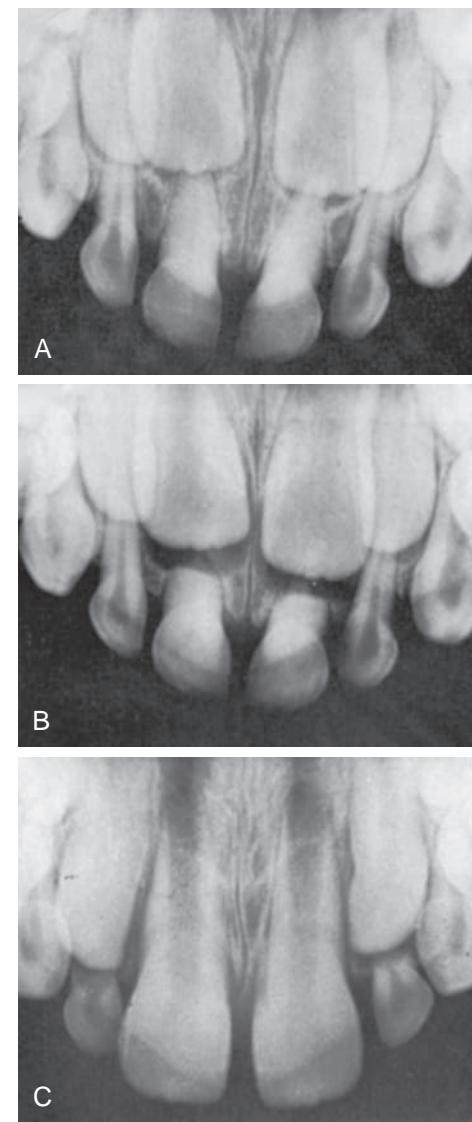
(A) Radiograph demonstrates almost complete obliteration of the pulp chambers and canals. (B) Normal root resorption of the primary incisors has occurred. (C) The permanent incisors have erupted.
